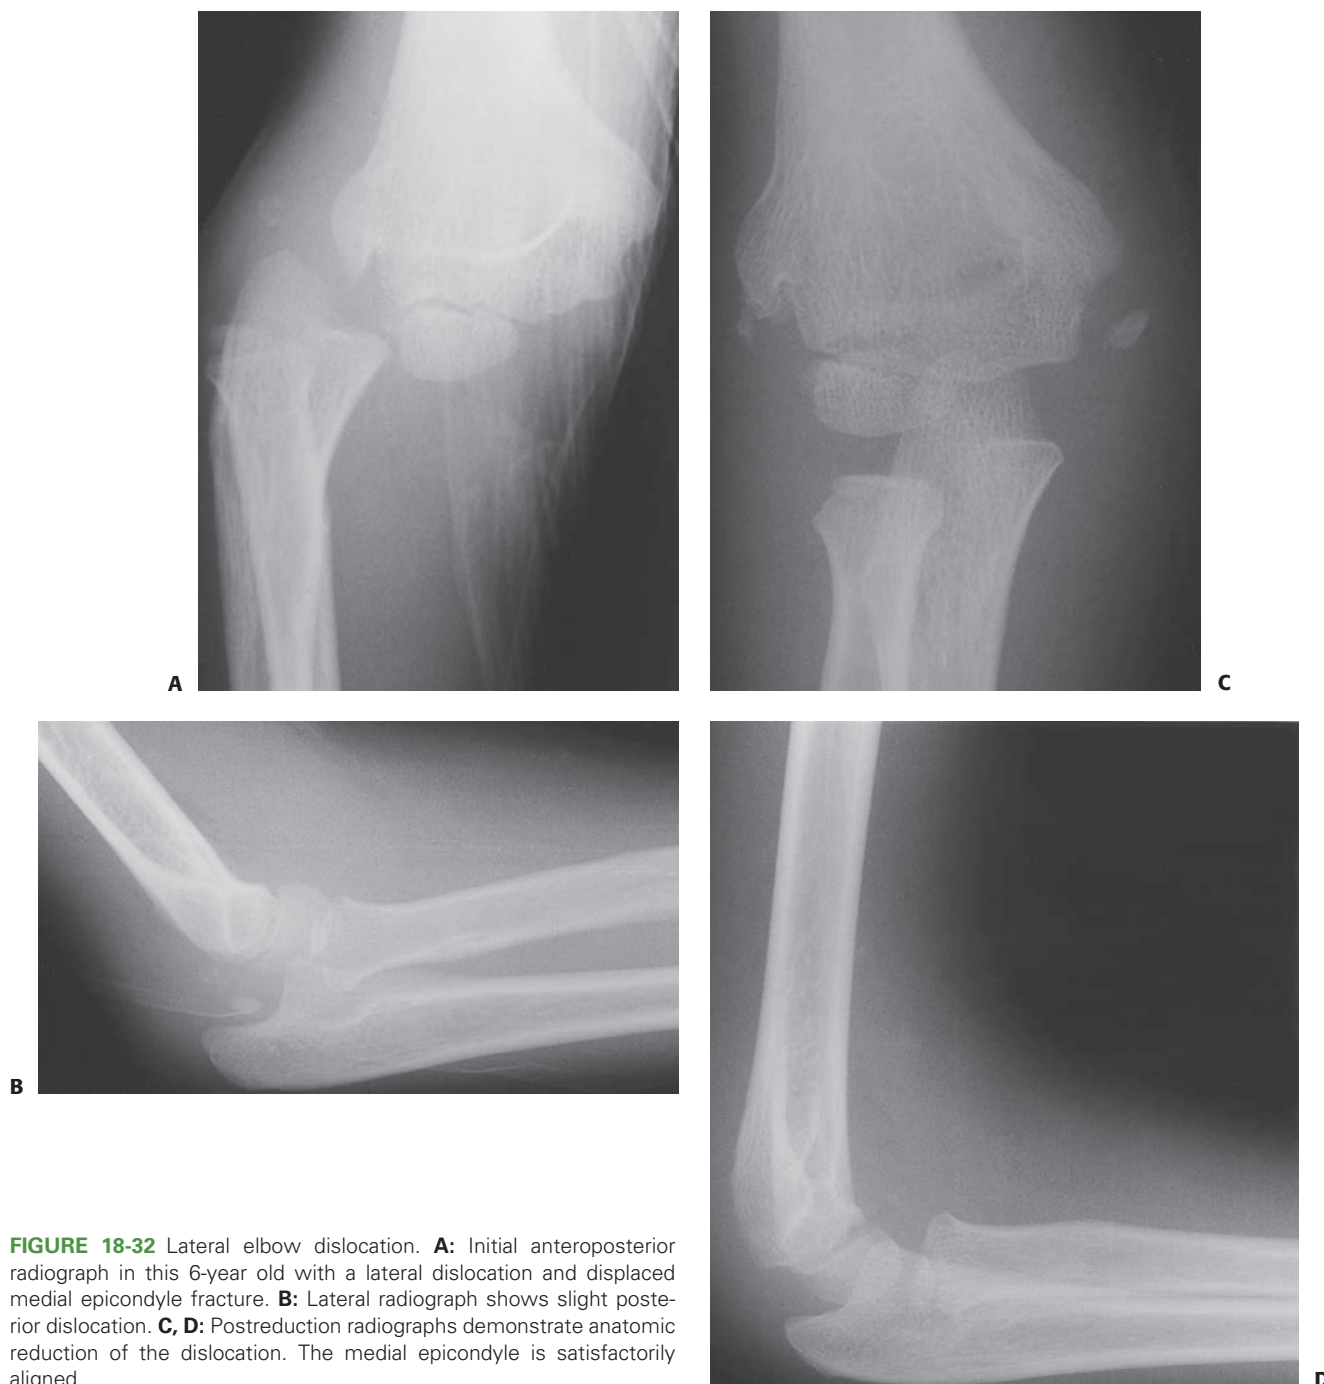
Lateral elbow dislocation. A: Initial anteroposterior radiograph in this 6-year old with a lateral dislocation and displaced medial epicondyle fracture. B: Lateral radiograph shows slight posterior dislocation. C, D: Postreduction radiographs demonstrate anatomic reduction of the dislocation. The medial epicondyle is satisfactorily aligned.
